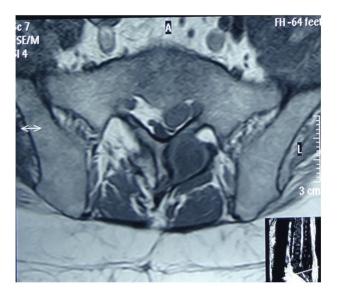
MRI of the lumbar spine showing a mass lesion, 2.5x2x2 cm, in left posterior paravertebral region at L5-S1 region and immediately adjacent to L5 lamina
